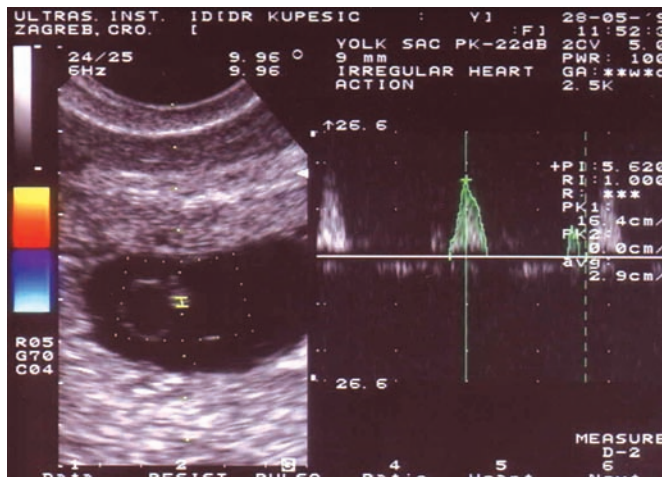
Pulsed Doppler signals derived from the yolk sac in a patient with missed abortion. Note larger diameter (7 mm) of the yolk sac and irregular blood flow signals at its periphery.
